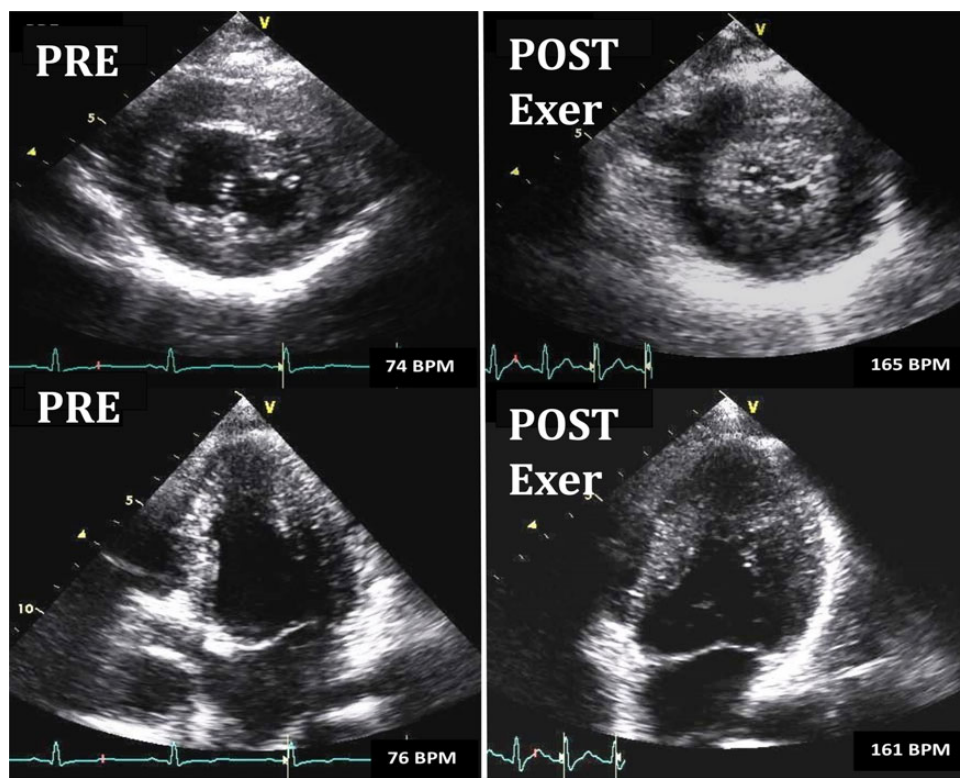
Exercise (Exer) SE in a 13-year-old patient with tricuspid atresia and single LV displaying end-systolic frames in the parasternal short axis (upper panels) and apical four-chamber (lower panels) views taken at rest (PRE) and peak exercise (POST). The displayed images showed the desired response of increased global myocardial thickening with a significant decrease in end-systolic volume.
